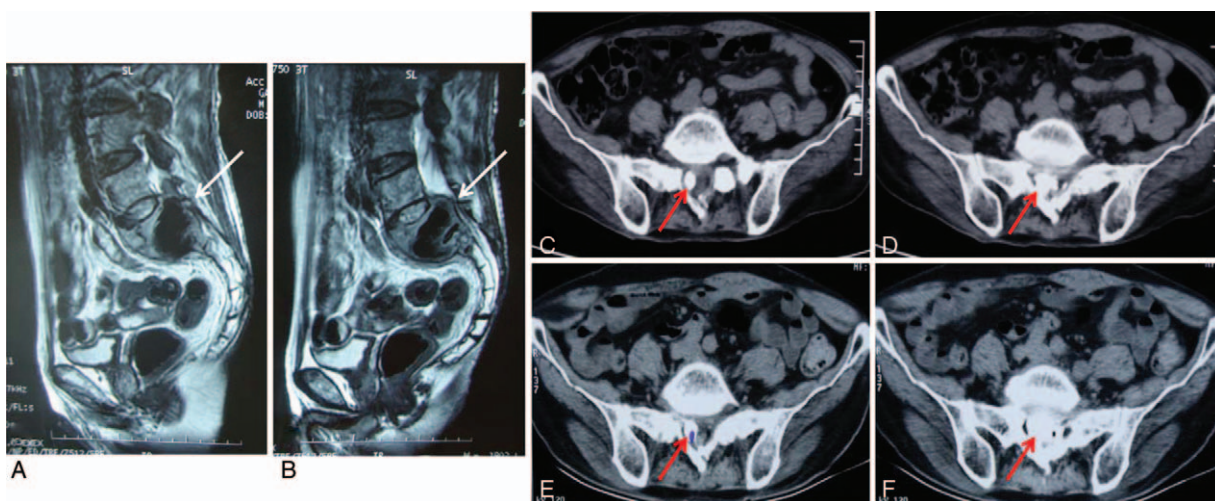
(A, B) Postoperative sagittal T2-weighted MRI scan in January, 2015. (C, D) Computed tomography of the sacral spine obtained postoperatively. (E, F) Computed tomography of the sacral spine obtained 6 months after the first surgery. MRI=magnetic resonance imaging.
